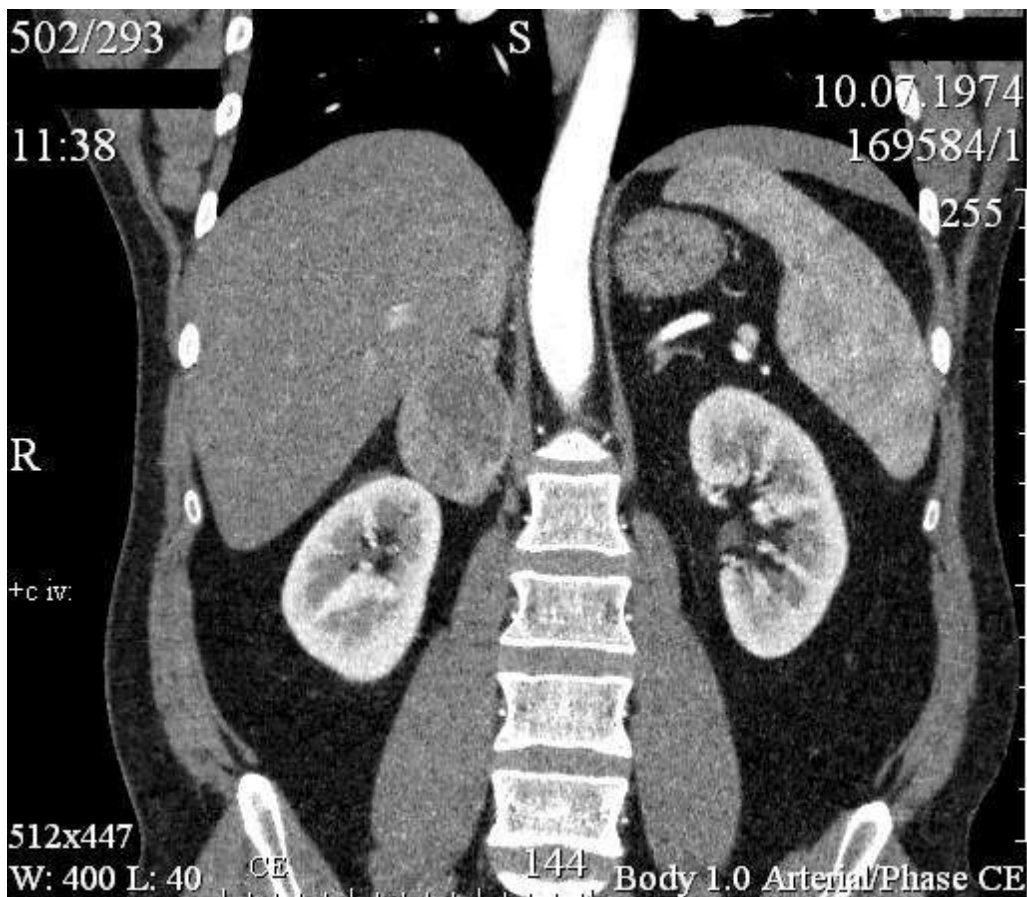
Carcinoma of the right adrenal gland. Computed tomography, arterial phase of the study.
